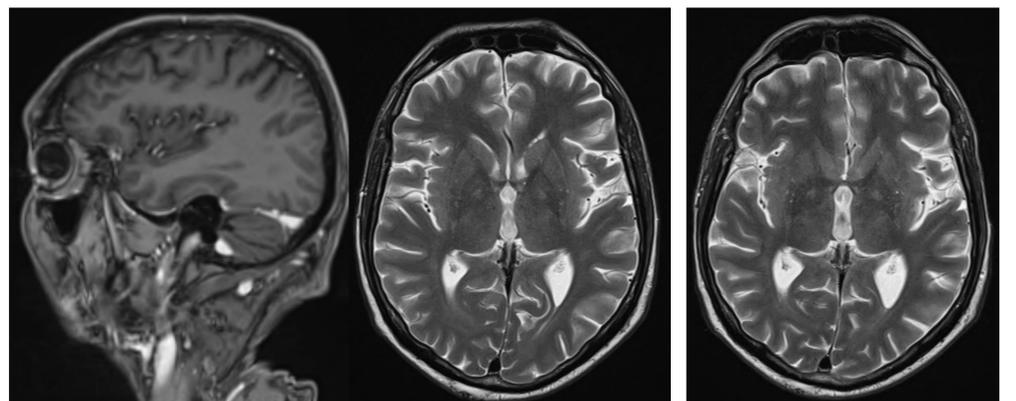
Complete resolution of all morphological findings on control MRI (T1 and T2 weighted images)
